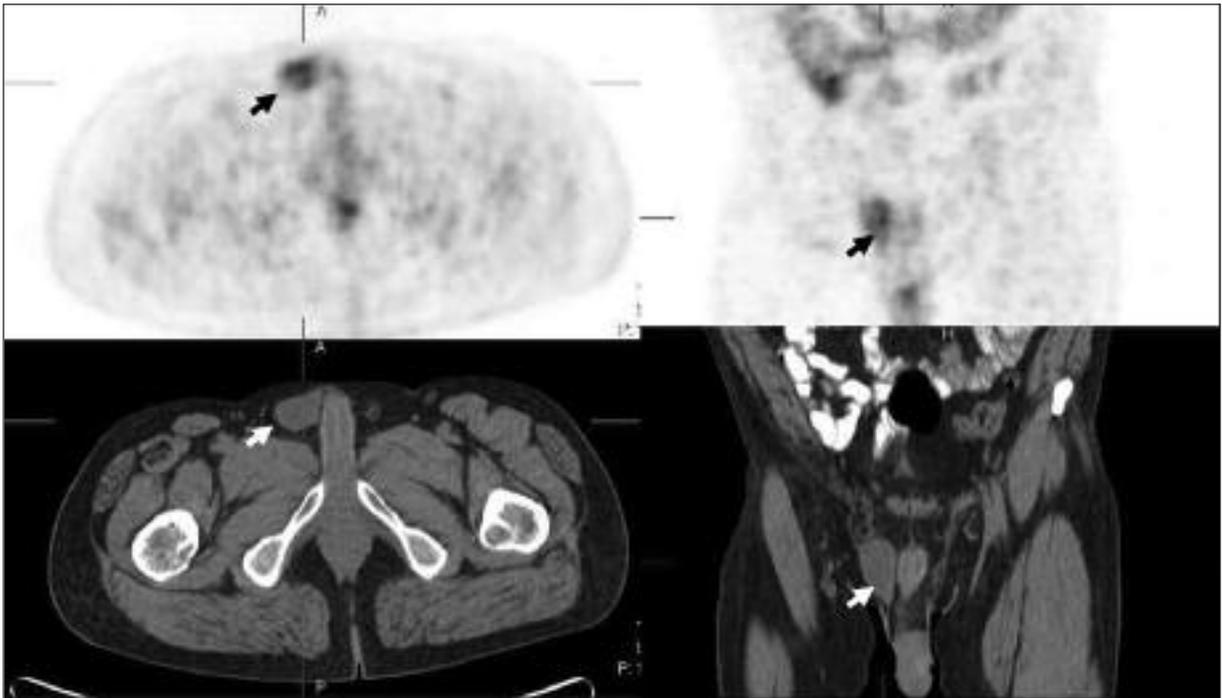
Retractable testis showed increased FDG uptake in the right inguinal area.
